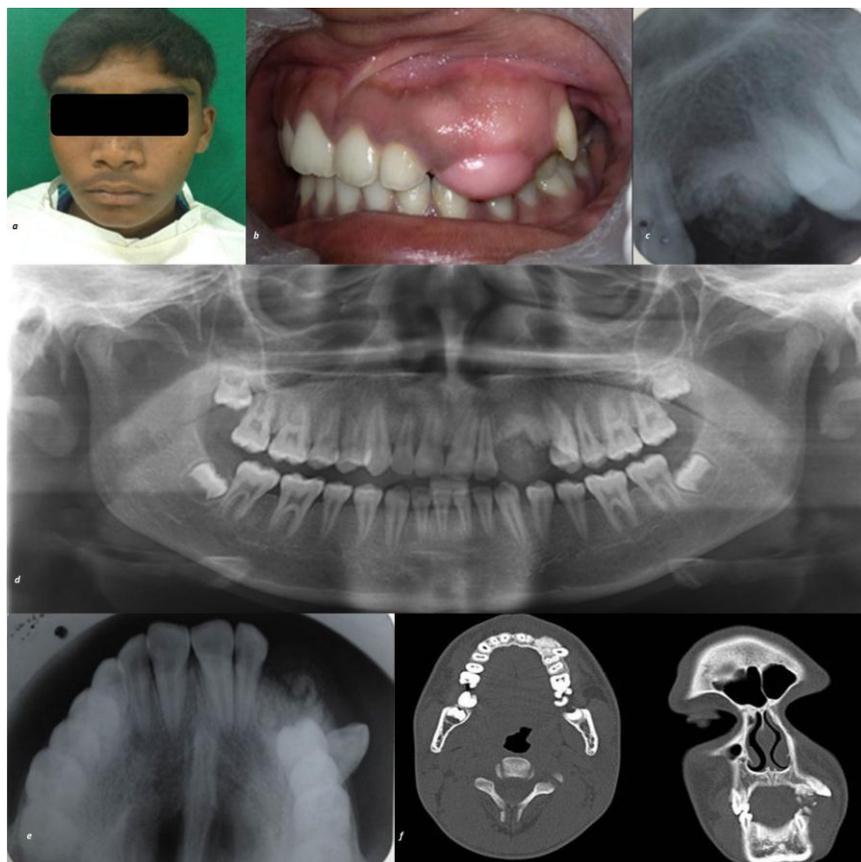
The photograph showing extra oral view (a) and intraoral (b) swelling on left maxillary gingiva. The Intraoral periapical radiograph (c), Orthopantomograph (d) and occlusal (e) radiograph reveals a well-defined mixed radiodensity in relation to 23 region with axial and coronal section of computed tomography (f) showing a hyperdense foci in relation to left maxillary region.
